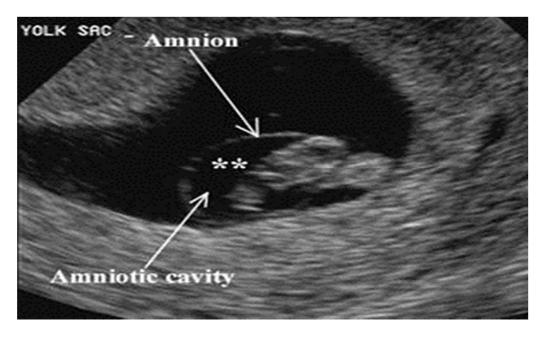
Sonographic image with amniotic cavity (Horrow MM1992).
